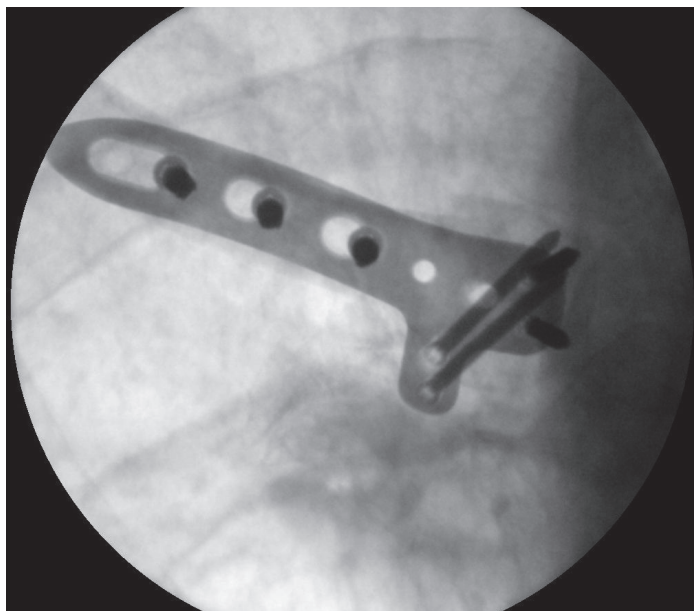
Intra-operative X-ray cranio-caudal
